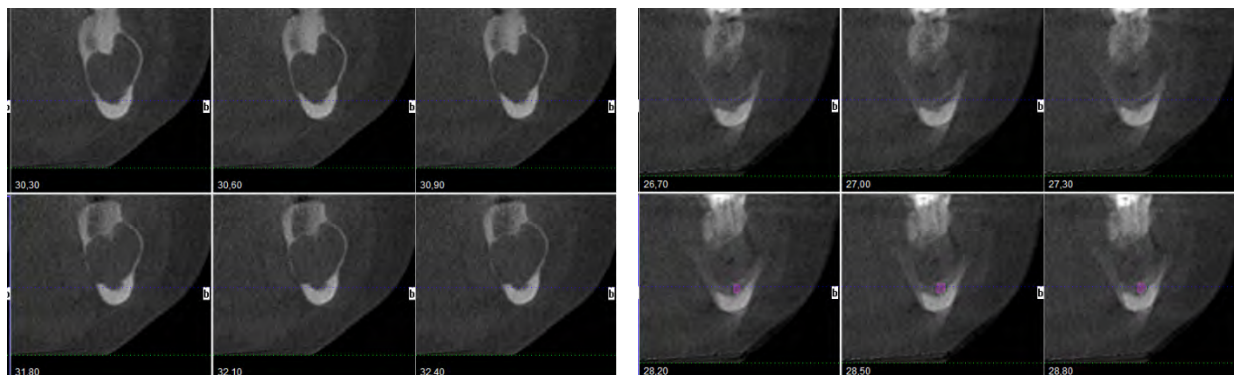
Pre- and post-decompression CBCT views
